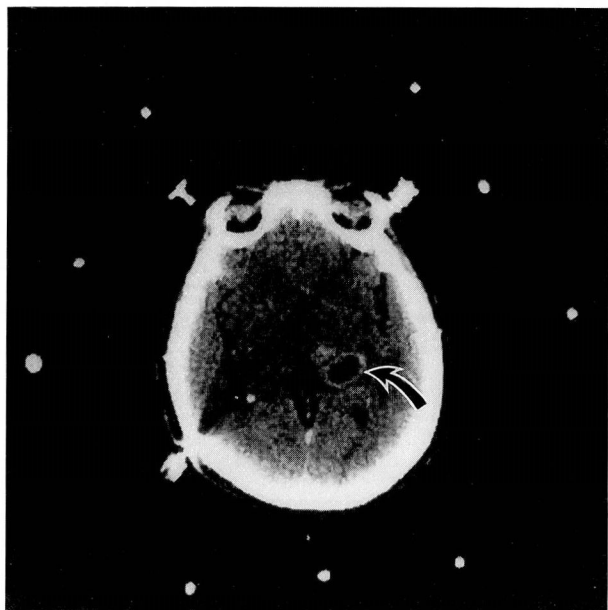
Stereotactic computed tomographic scan showing lesion (arrow) and nine reference marks. Ratio of distances between markers within each triad defines location of the central marker with respect to the head-ring. Localization of all three central markers defines the imaging plane.
